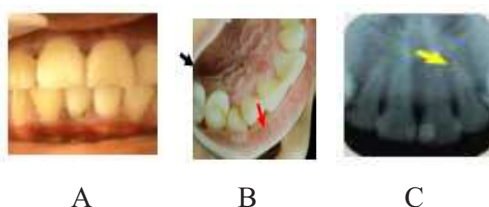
Initial photo of tooth 21. A) There appears a brownish black shadow on the mesio-incisal side of the tooth 21. B) On the palatal part there is a gap between the teeth with a fairly clear blow with the blackish brown on the slit indicated by the black arrow. C) Radiographic examination results show diffuse periapical lesions (yellow arrows)
